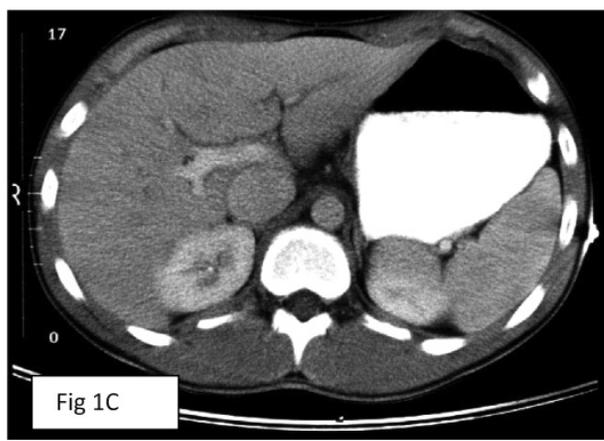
CT abdomen showing liver, normal in size and echo texture.
